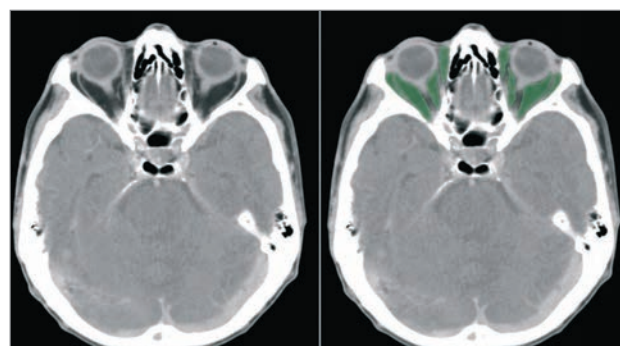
Representative axial head CT image before (left) and after (right) semi-automated segmentation of bilateral orbital adipose tissue (green overlay) used for radiomic feature extraction
